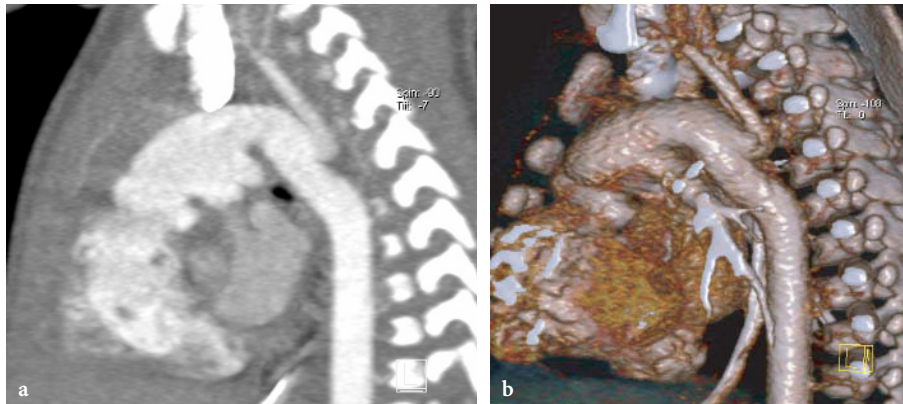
64-slice CT examination of a neonate. The image is displayed in MIP (a) and VRT (b). With a 0.33-s rotation time, the thorax of the neonate is covered in less than 2 s
